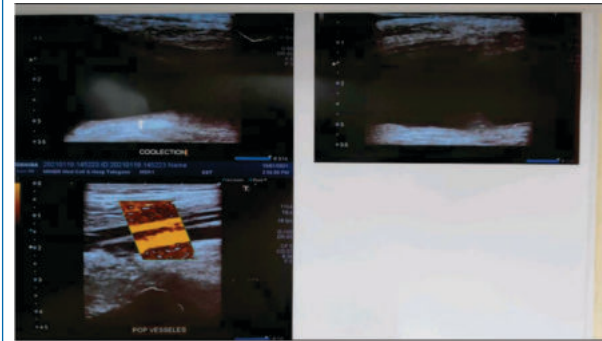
Ultrasonography of knee
